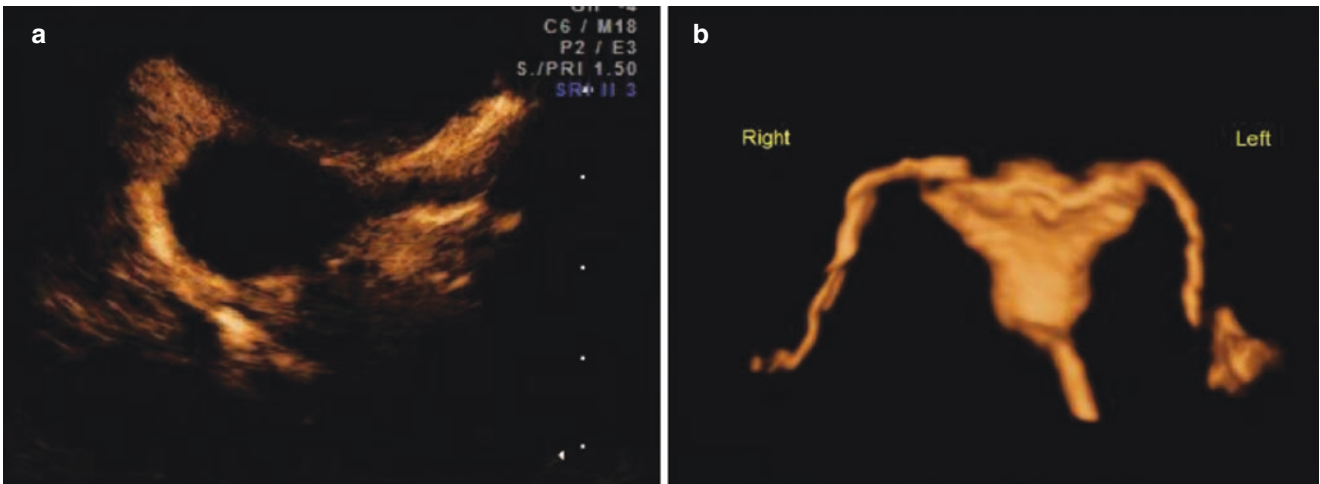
Salpingography of the patent fallopian tube (positive contrast agent). (a) The contrast agent is around the ovary in the pelvis; (b) Three-dimensional ultrasound shows that the fallopian tubes are unobstructed
